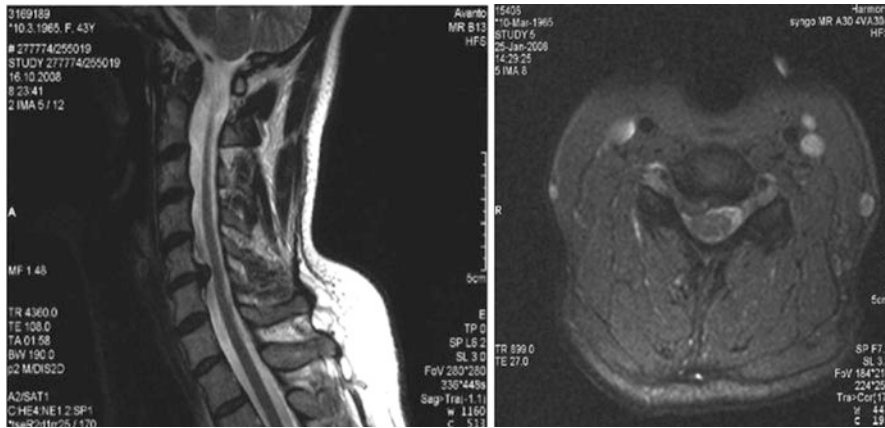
MRI showing a typical indication for cervical disc arthroplasty – a single level soft disc herniation causing radiculopathy refractory to conservative treatment
